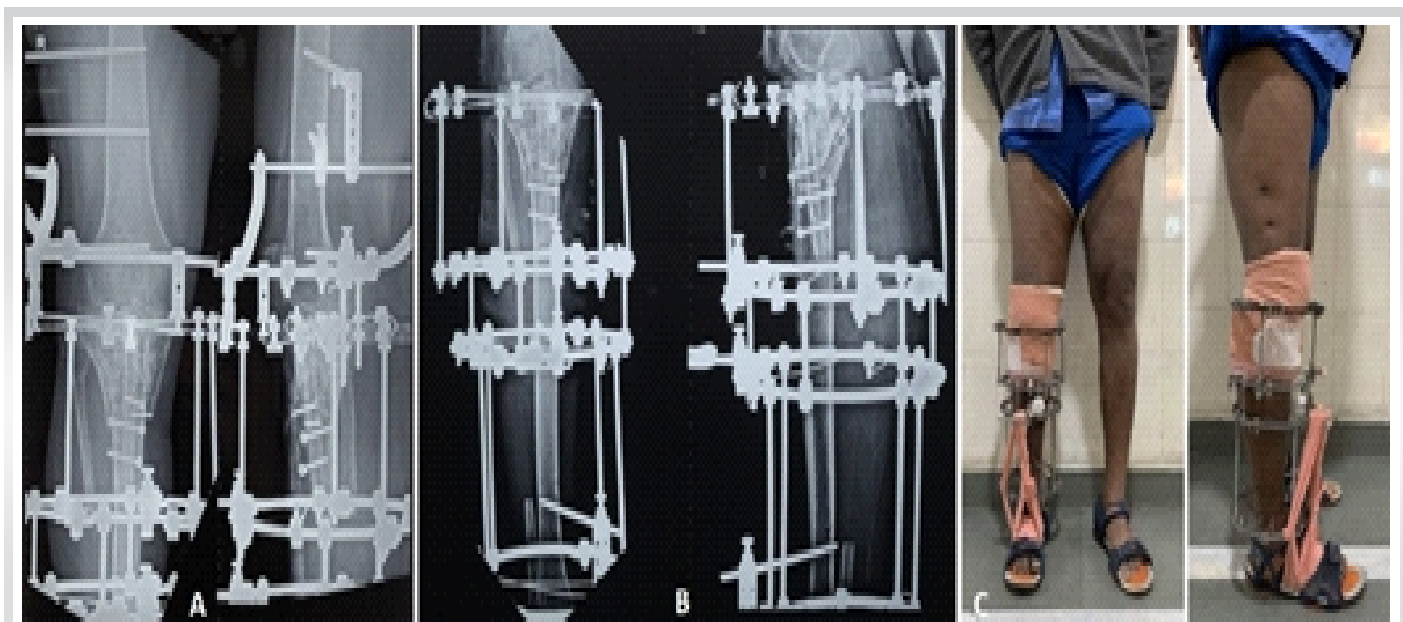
(a) Anteroposterior and lateral radiographs of the knee joint demonstrating the radiolucent carbon-fiber ring over the joint and position of subchondral “raft” wires; (b) radiographs following removal of the knee-spanning portion of the frame; (c) clinical images following removal of the knee-spanning portion of the frame.
